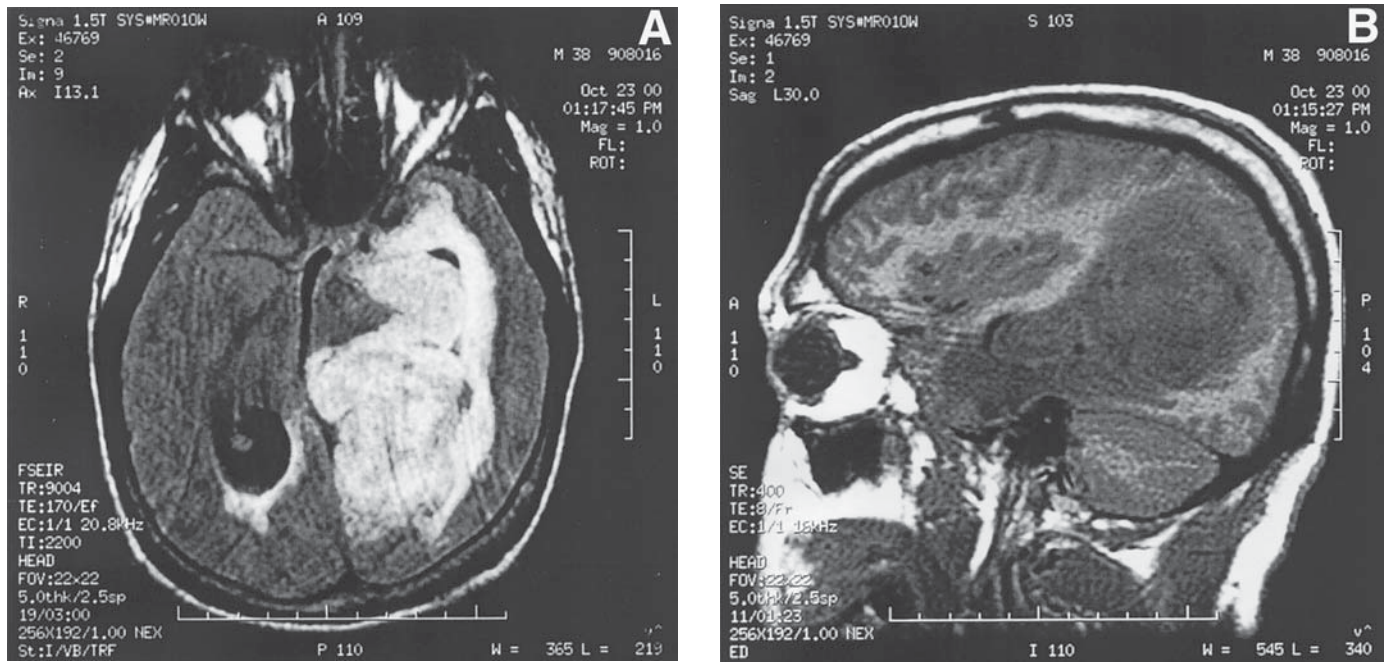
(A)(B). This 29-yr-old man had a 6-mo history of increasing headaches, worse in the morning and at night. Memory loss and cognitive problems began 1 mo prior to diagnosis. As the headache progressed and became very severe he presented to the emergency department. MRI revealed a large intracranial tumor with edema, midline shift, and a “trapped” posterior horn of the lateral ventricle consistent with obstruction of CSF flow. Surgery demonstrated a grade 3 oligodendroglioma. He received postoperative radiotherapy and chemotherapy with improvement of his headache.
